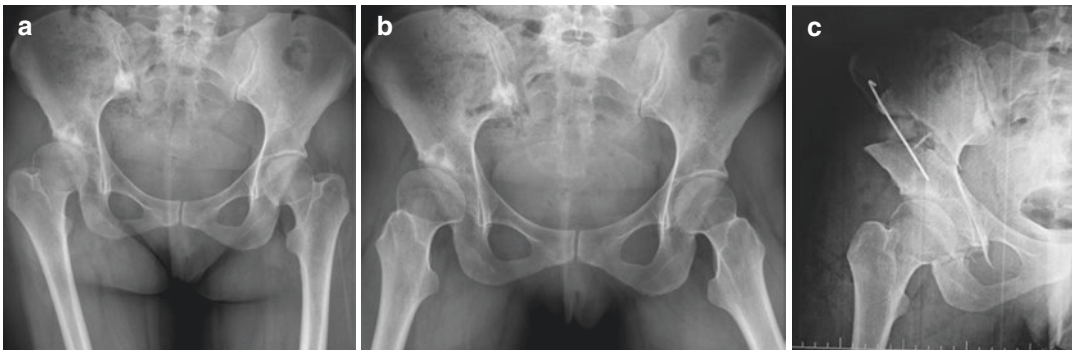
(a) AP X-ray of a 34-year-old woman showing dysplasia of the right hip. Subchondral cyst at the acetabulum is an indicator of the onset of degeneration and osteoarthritis. (b) Abduction-internal rotation AP X-ray showing concentric reduction of the hip, which means that
